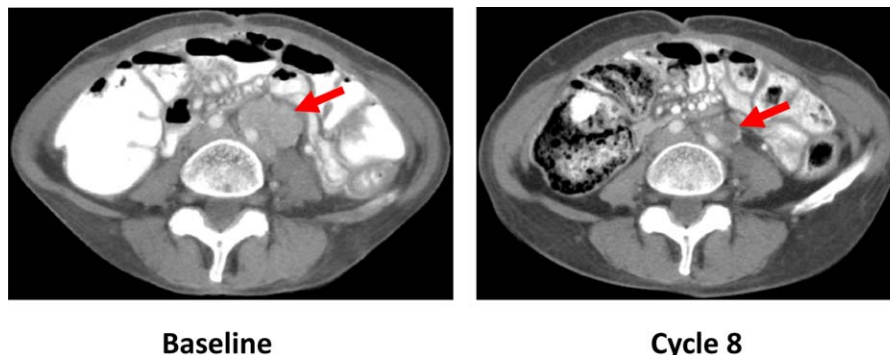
Partial response in a patient aged 54 years with poorly differentiated vaginal adenocarcinoma treated with pilaralisib tablets 200 mg once daily. Sequential computed tomography scans of the abdomen show a 32% interval reduction of a left para-aortic soft tissue mass in Cycle 8, compared with baseline. Overall tumor reduction was 21% in Cycle 8.
